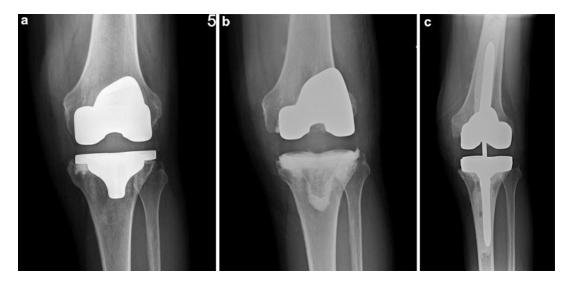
Vignette 5: Infected total knee replacement. (a) AP radiograph showing a cemented total knee replacement that is infected. A lucency is seen under the cement on the lateral side of the tibial tray. (b) AP radiograph showing an
